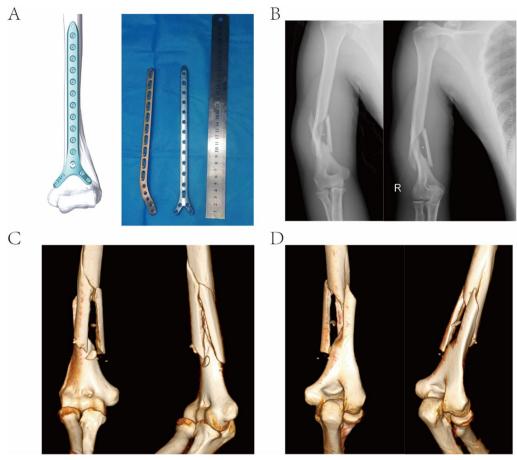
Patient plate with preoperative X-ray and computed tomography (CT) 3D pictures. A Anterior anatomical locking plate of distal humerus; width: 13 mm, thickness: 3 mm, distal angle: 60°, length: 136 mm, 152 mm, 168 mm, 184 mm, 200 mm, and 232 mm (option of six models). B Anteroposterior radiographs of the distal humerus of the patient within 6 hours after injury. C, D CT–3D scan pictures of the patient within 6 hours after injury
